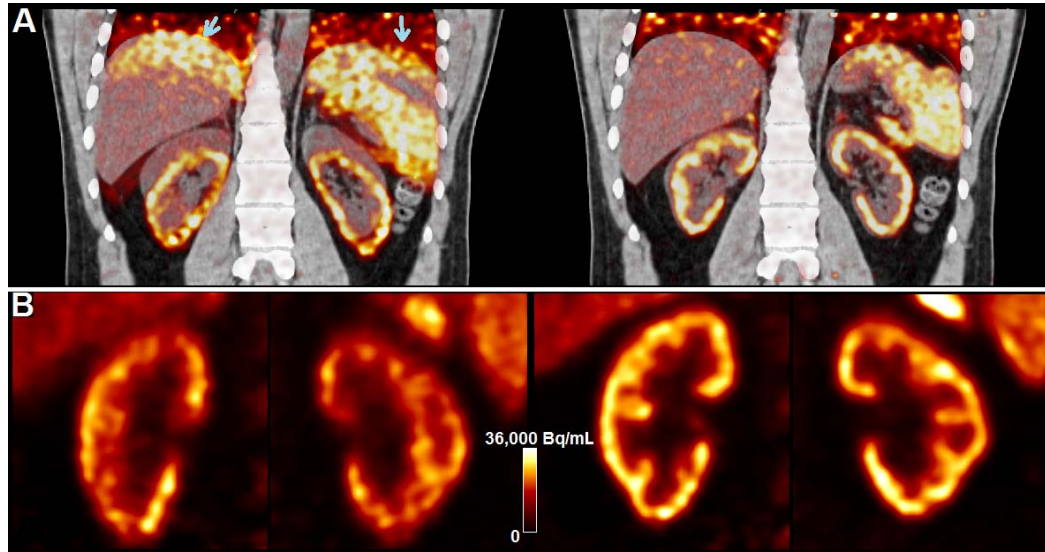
A. Inspiration- (left) and expiration- (right) phase gated PET reconstructions superposed with CT for a sample ^{18}F -FPDTBZ study. Arrows in A (left) point to attenuation-mismatch. B. Inspiration- (left) and expiration- (right) phase PET reconstruction of kidneys.
